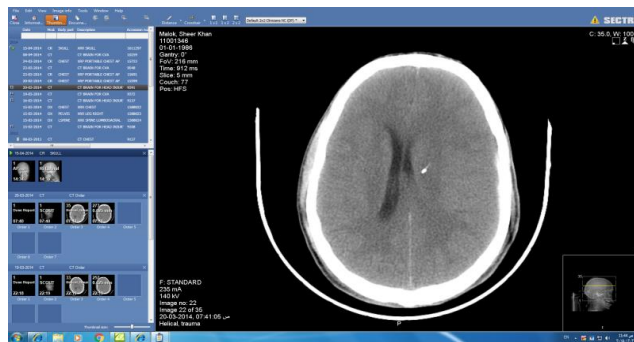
CT brain shows left subdural hematoma with multiple contusions. Width (Px): 1920, Height (Px): 1080 Color Depth: 24 bit(True color)
